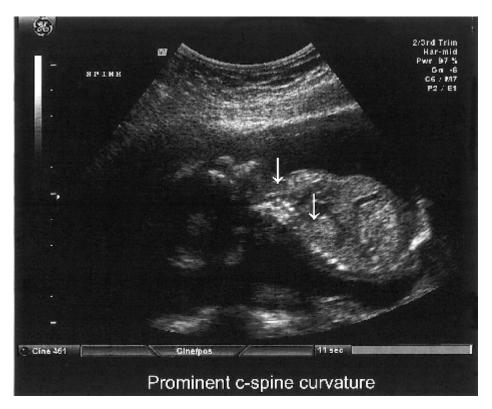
Sonogram of a 16-week, 6-day-old fetus with prominent c-spine curvature.
